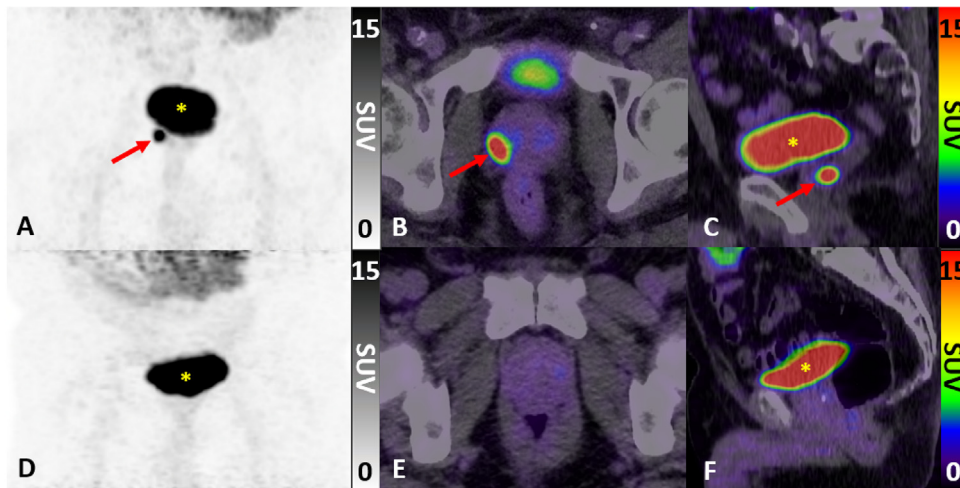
PSMA PET/CT examples from the PRIMARY trial. (A–C) Patient with PSA 5.0 ng/ml, prostate volume of 36 ml and PI-RADS 2 score on MRI, and PSA density 0.139 ng/ml². PSMA PET/CT revealed a PRIMARY score of 5 with a highly avid focus (SUVmax 25) in the right peripheral zone at mid level shown on (A) MIP, (B) fused transaxial and (C) sagittal planes. Transperineal prostate biopsies revealed prostate adenocarcinoma, Gleason score 4 + 3 = 7 (85% pattern 4). (D–F) Patient with PSA 6.3 ng/ml, prostate volume of 46 ml and PI-RADS score 2 on MRI, and PSA density of 0.137 ng/ml². PSMA PET/CT revealed a PRIMARY score of 1 without any PSMA-avid foci as shown on (D) MIP, (E) fused transaxial, and (F) sagittal planes. Transperineal prostate biopsies did not reveal any sites of malignancy. * = bladder (physiological); CT = computed tomography; MIP = maximum-intensity projection; MRI = magnetic resonance imaging; PET = positron emission tomography; PI-RADS = Prostate Imaging-Reporting and Data System; PSMA = prostate-specific membrane antigen; PSA = prostate-specific antigen; SUVmax = maximum standardised uptake value.
